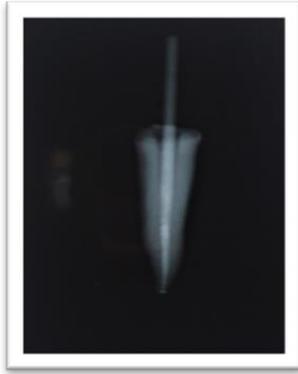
Radiographic image of fit of glass fiber post Fig 2: Radiographic image of fit of Edelweiss post
